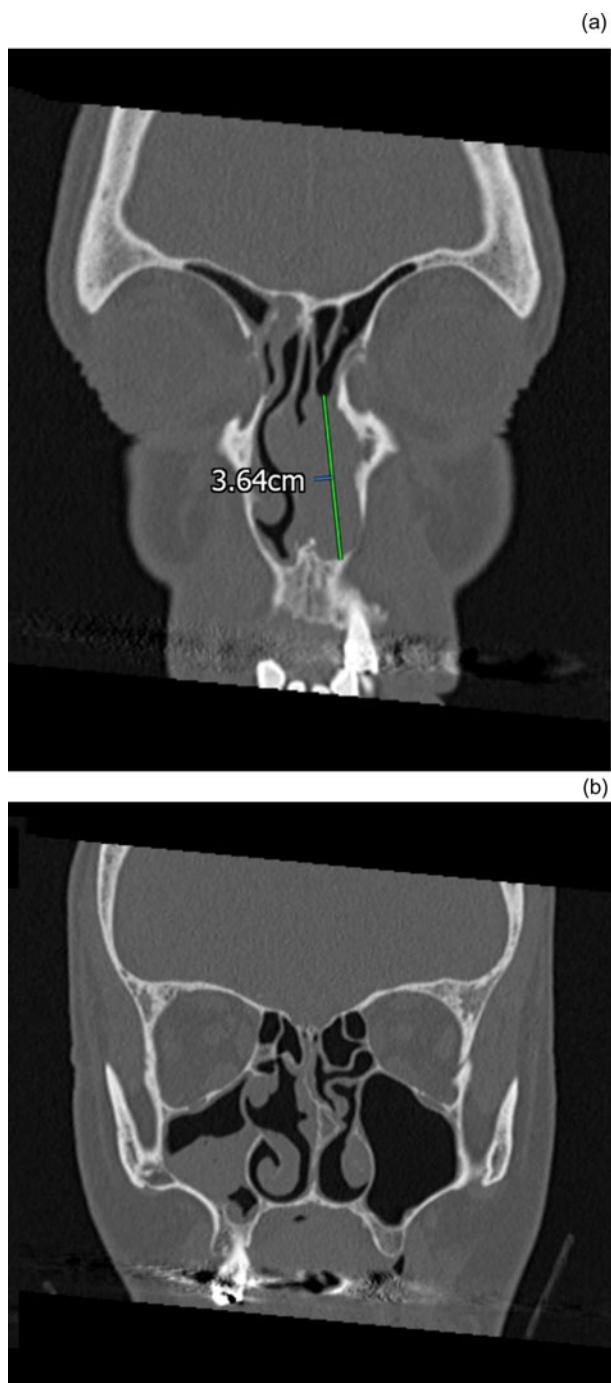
Coronal computed tomography sinus scans in bone window of a patient with primary nasal lymphoma. (a) A well-defined soft tissue mass with homogeneous attenuation within the anterior half of the left nasal cavity. (b) Incidental finding of right-sided maxillary partial opacification in the same patient.
